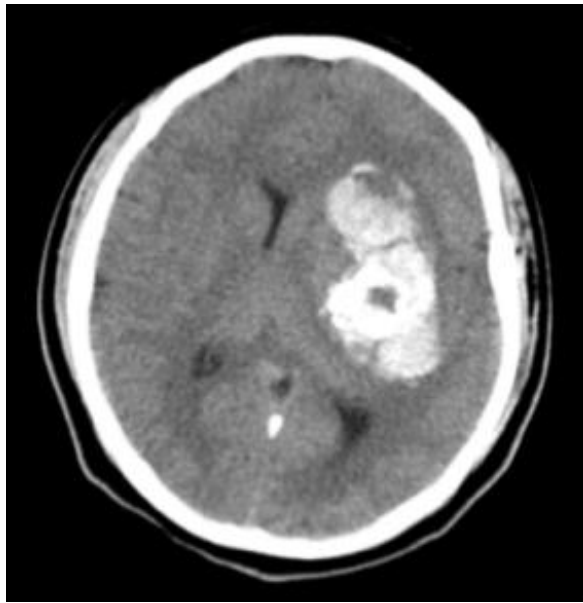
Brain CT. Ruptured left thalamic AVM
